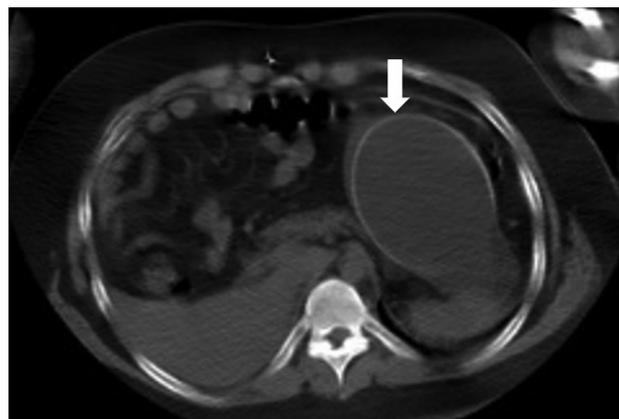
Abdominal CT showing the distal end of the VP shunt catheter in contact with the stomach walls
